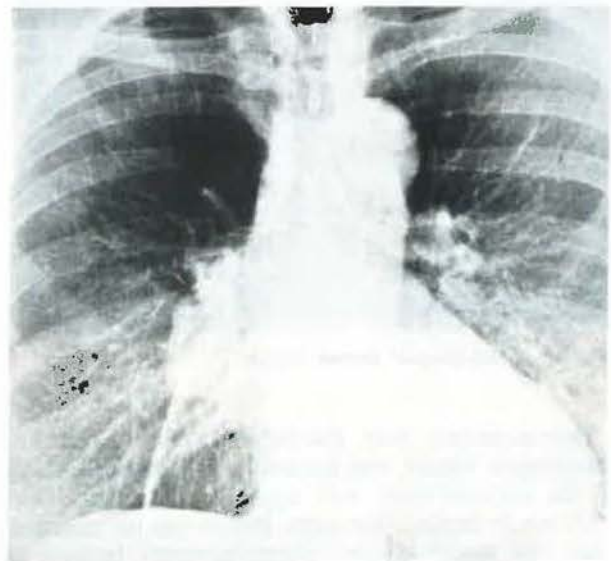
Radiograph on admission.
